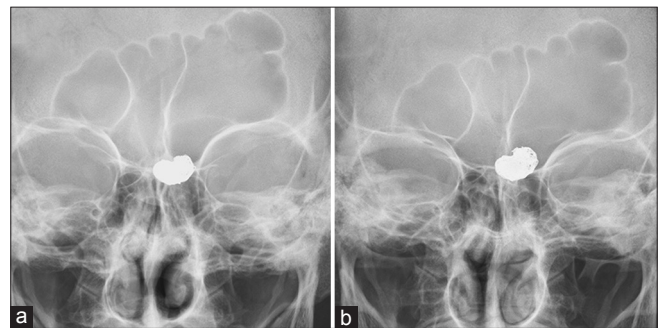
The coil was followed by an X-ray. The image soon after the embolization (a) and a year after the procedure (b) are demonstrated. The coil mass showed minimal conformational change.
